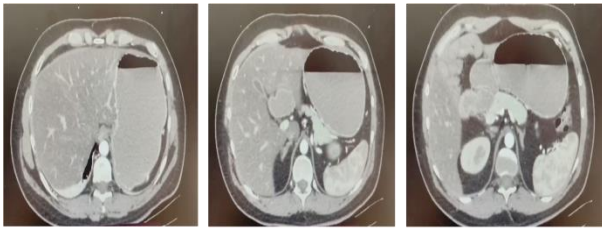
A computerized tomography (CT) scan of the abdomen was performed revealing duodenum that does not cross the midline in its third part, duodeno-jejunal junction in the right hemiabdomen; cecum located in the pelvis and lateralized to the left, with left ascending colon, findings suggestive of intestinal malrotation.
